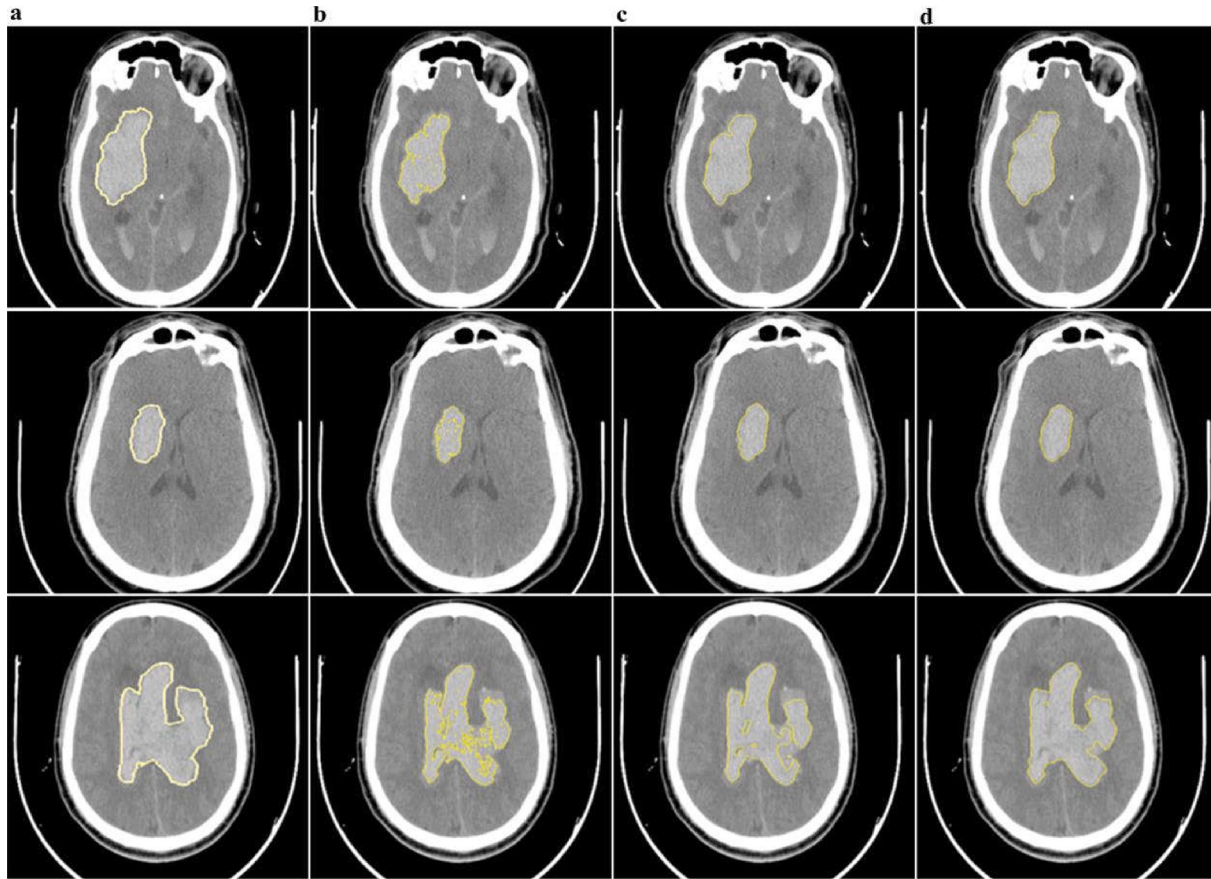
Hemorrhage segmentation of CT image: column (a) original image (b) FCM clustering method (c) Manual fuzzy based active contour method (d) Proposed method.
